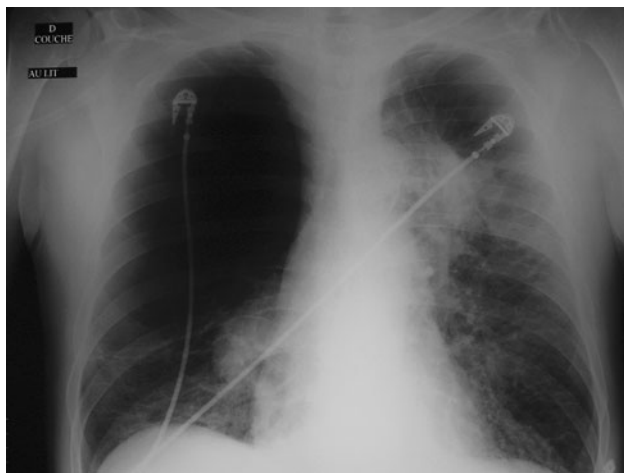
Thoracic radiography. Note the absence of parenchyma in the right upper segment
